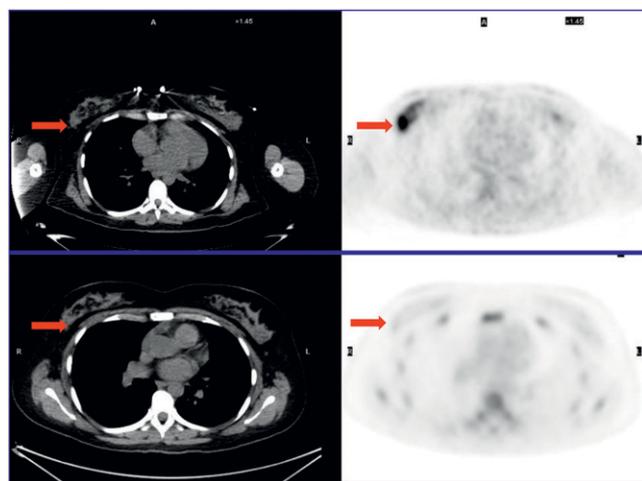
" ^{18}F -FPPRGD₂ PET/CT $\alpha_v\beta_3$ integrin expression imaging in breast cancer. Images acquired with (top) ^{18}F -FPPRGD₂ and (bottom) ^{18}F -FDG.
